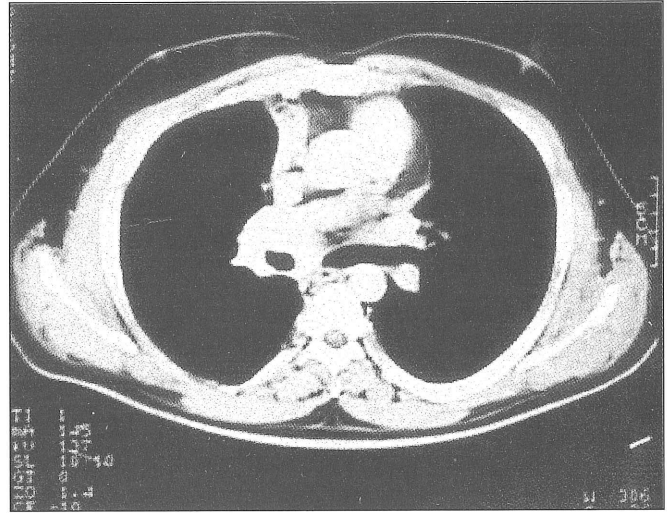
Stable mass lesion on CT scan after 5 years
